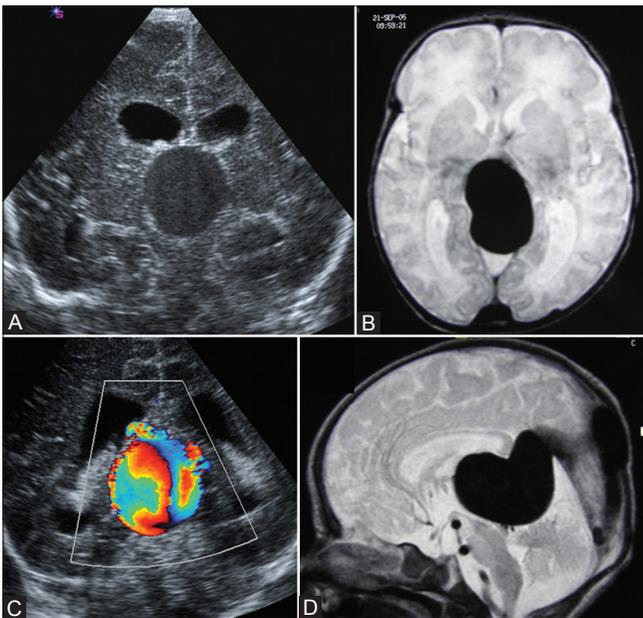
(A-D): Gray-scale and Doppler coronal USG demonstrating a cystic midline structure in the region of posterior third ventricle with mass effect. (A) Typical swirl effect is noted on Doppler (B). Findings are highly suggestive of aneurysmal malformation of the vein of Galen. The corresponding axial and sagittal T2W images of MR examination confirming large aneurysmal dilatation of the vein of Galen (C and D)
